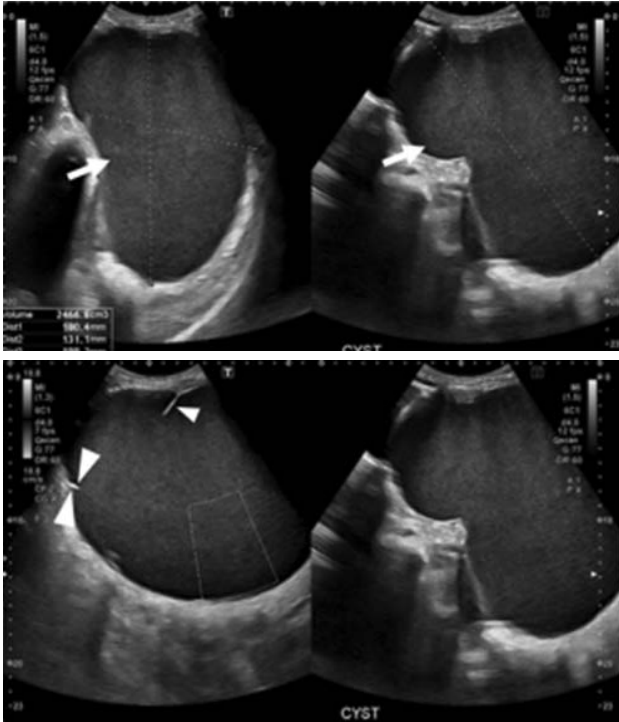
Grayscale ultrasound images showing a cyst with homogeneous internal echoes (arrows) and incomplete internal septations (arrowheads).
